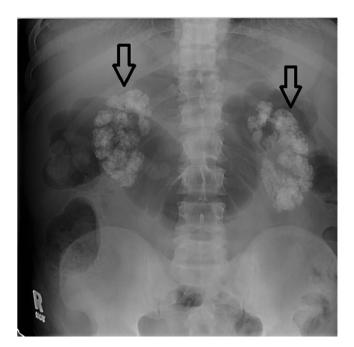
Plain radiography of the abdomen demonstrating bilateral nephrocalcinosis (*transparent arrow*).
